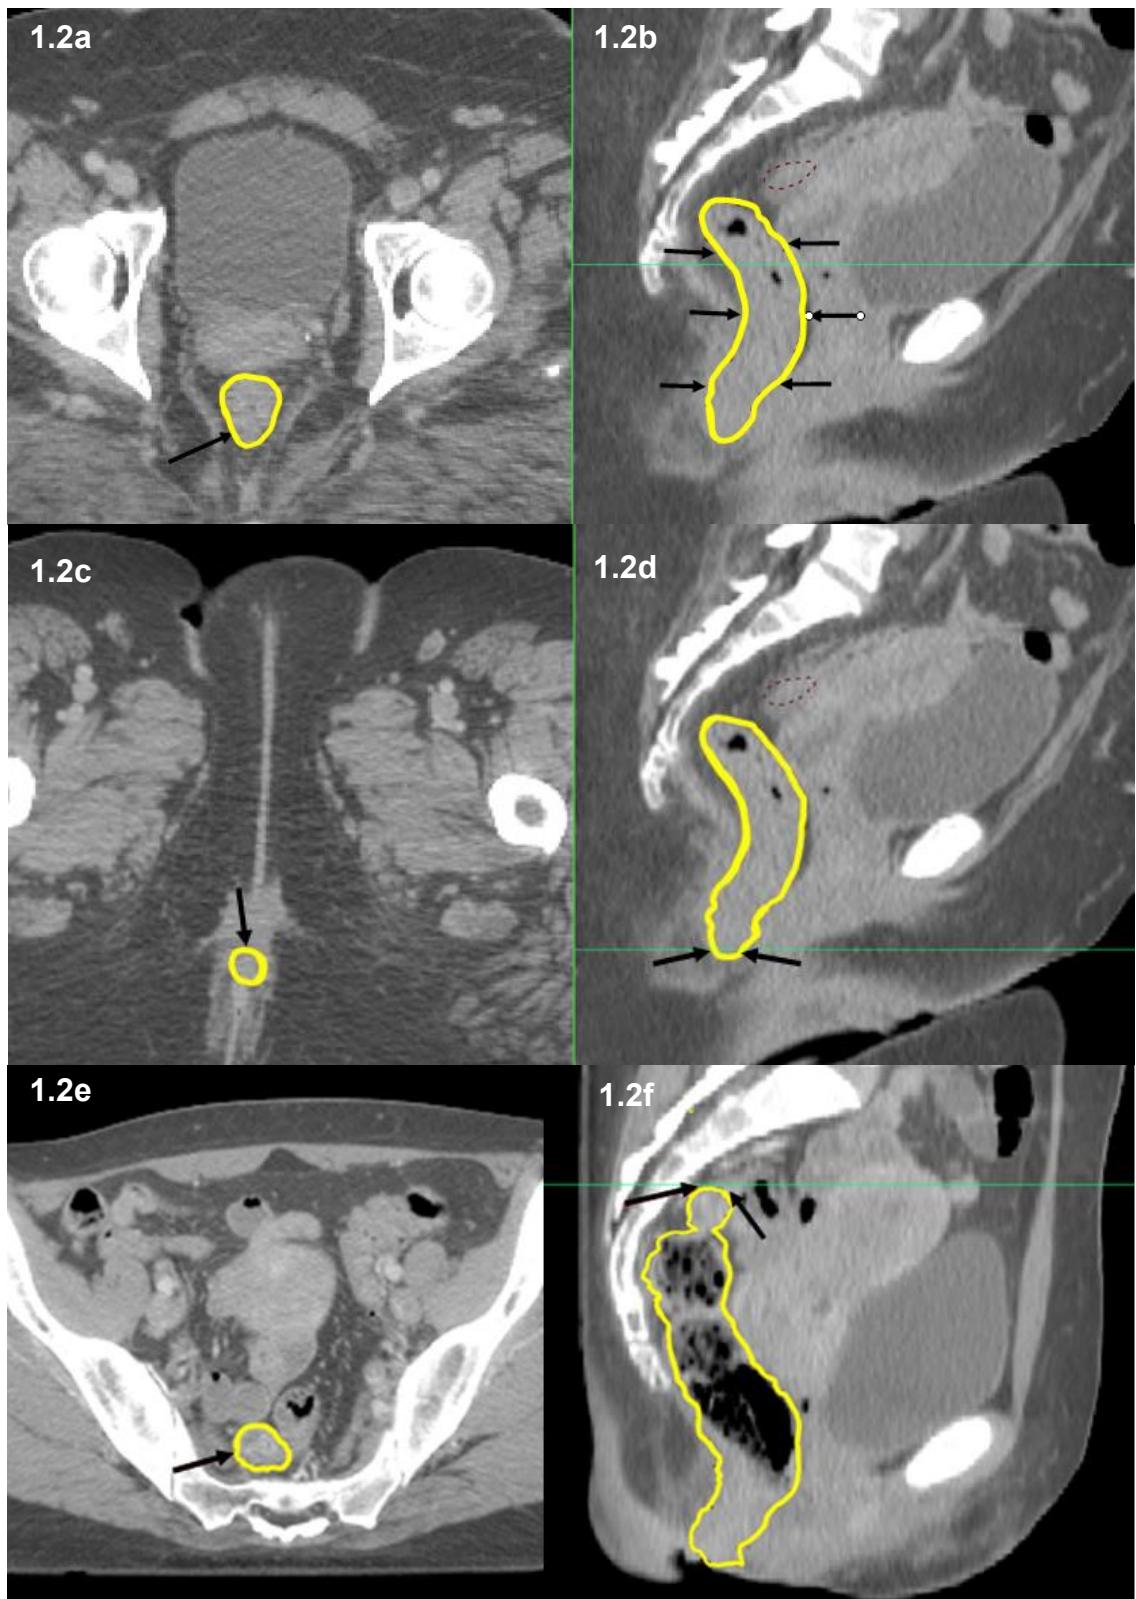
Axial (a) and Sagittal (b) CT at level of mid femoral heads with rectum outlined (yellow); Axial (c) and sagittal (d) CT at level of anus; Axial (e) and sagittal (f) CT at level of transition to sigmoid colon (arrowed)
